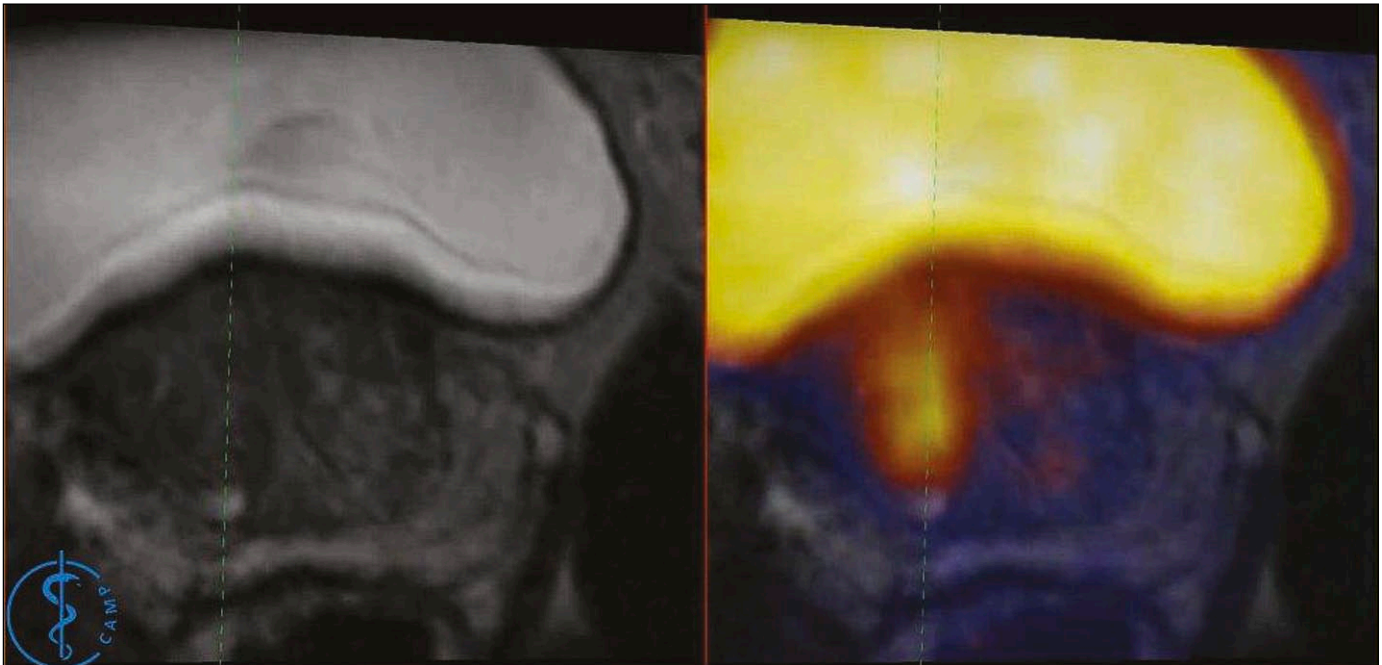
Screenshot of the overhead screen in Figure 2. The dotted green lines superimposed on the MR and PET images correspond to the projected biopsy direction provided by the US system using a 2D transrectal probe. PET/MR images may be used as in this example to help identify the biopsied lesion more accurately, but are not required.
